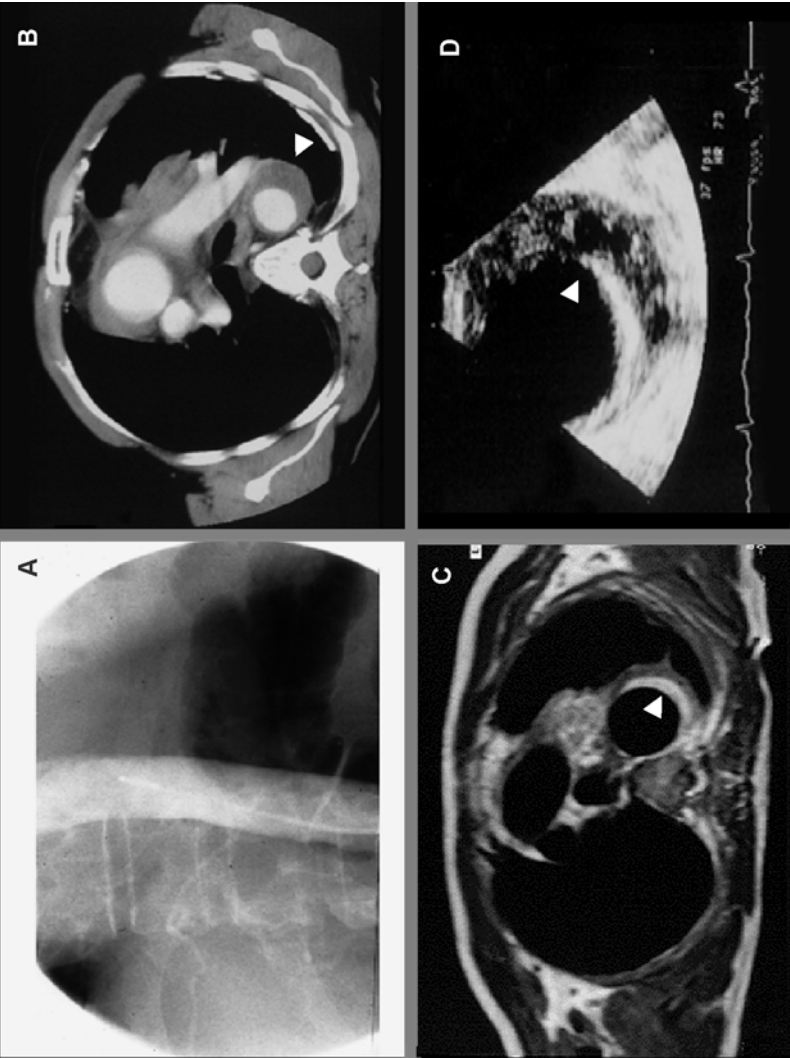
IMH in descending aorta by four imaging techniques. A. Aortography revealed no abnormalities. B. CT showed an IMH in proximal descending aorta and periaortic hematoma. C. CMR disclosed a hyperintense signal identifying the hematoma. D. TEE showed the same IMH with echolucent areas.
